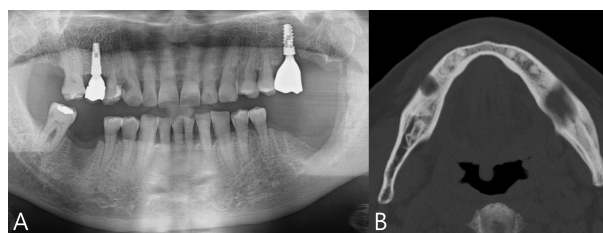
Radiographic image showing progression of bone healing.
